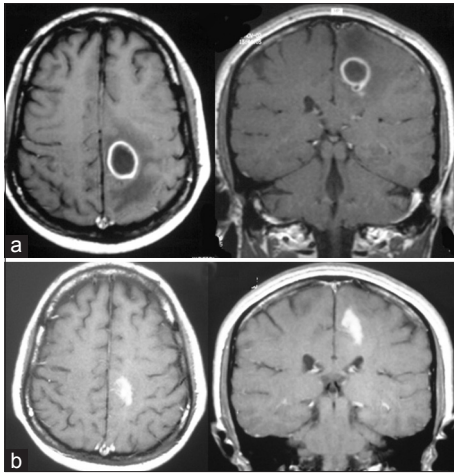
Axial T1-weighted postcontrast magnetic resonance imaging scan ring enhancing lesion at presentation (a) and 4 weeks after treatment (b).
